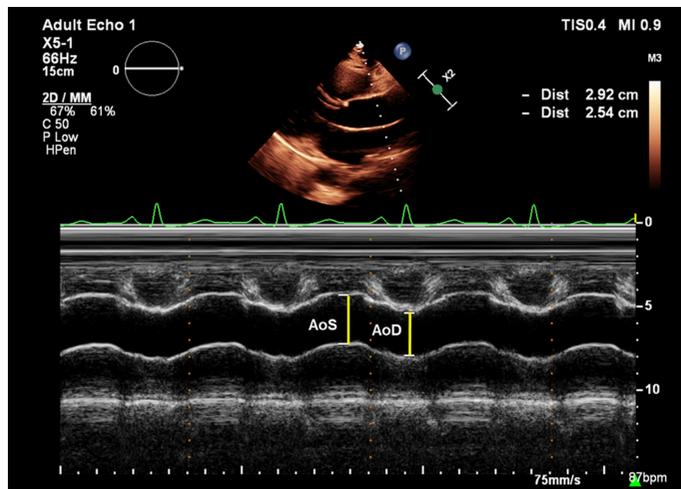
Parasternal long-axis view with M-mode echocardiography showing measurements of systolic aortic diameter (AoS) and diastolic aortic diameter (AoD) from the ascending aorta.
